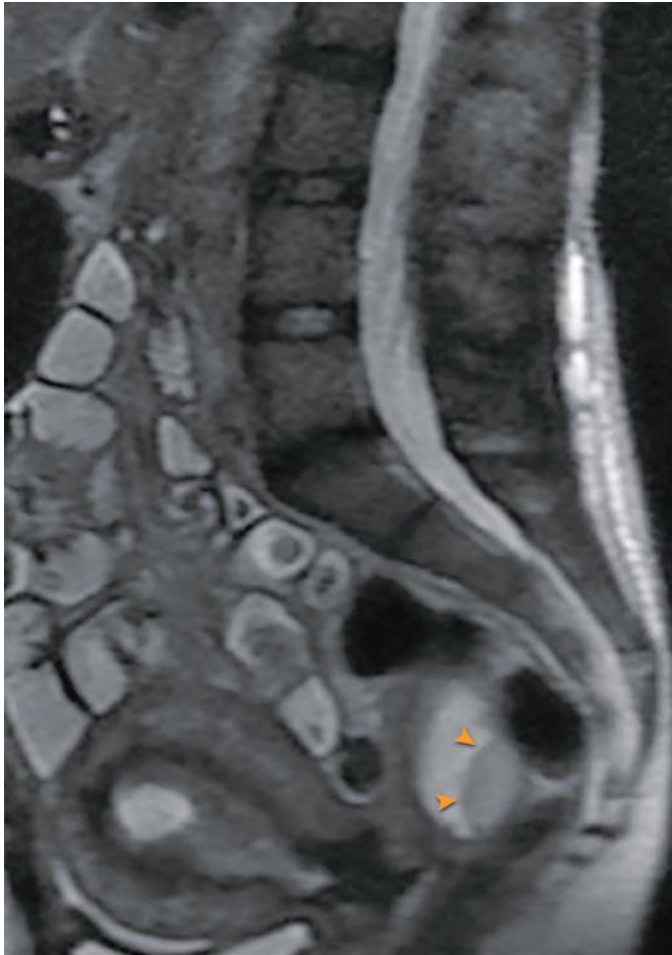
Ruptured appendicitis at 6 weeks' gestation. Sagittal T2-weighted imaging demonstrates complex fluid collection with fluid-debris level (arrowheads) consistent with abscess in the cul-de-sac. Surgery confirmed ruptured appendicitis with resultant abscess; intra-uterine fetal demise occurred 3 days later.
